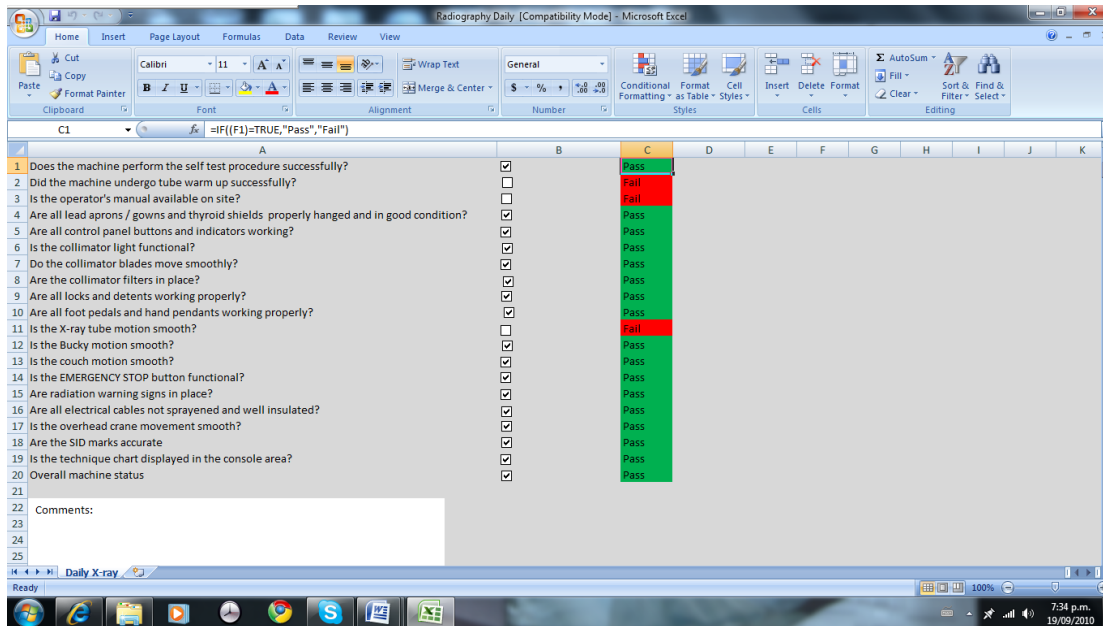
A screen capture showing the daily X-ray quality control test results page.
